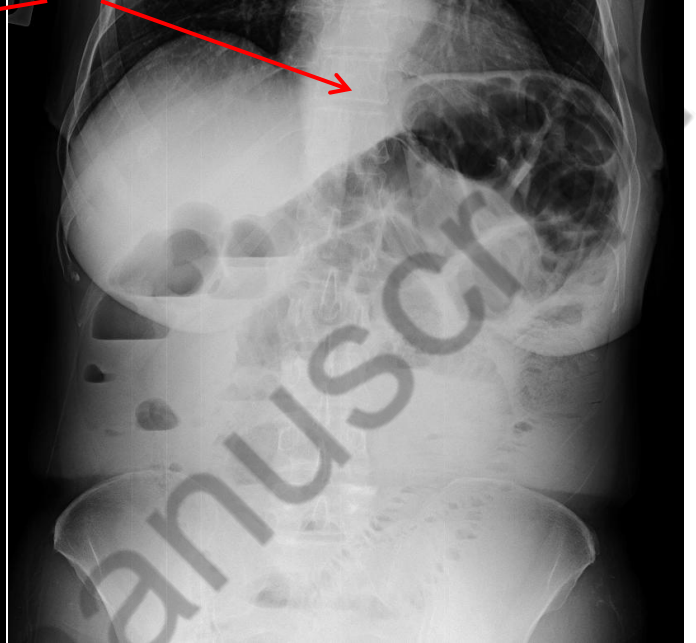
Abdominal radiograph before IVIG therapy.
